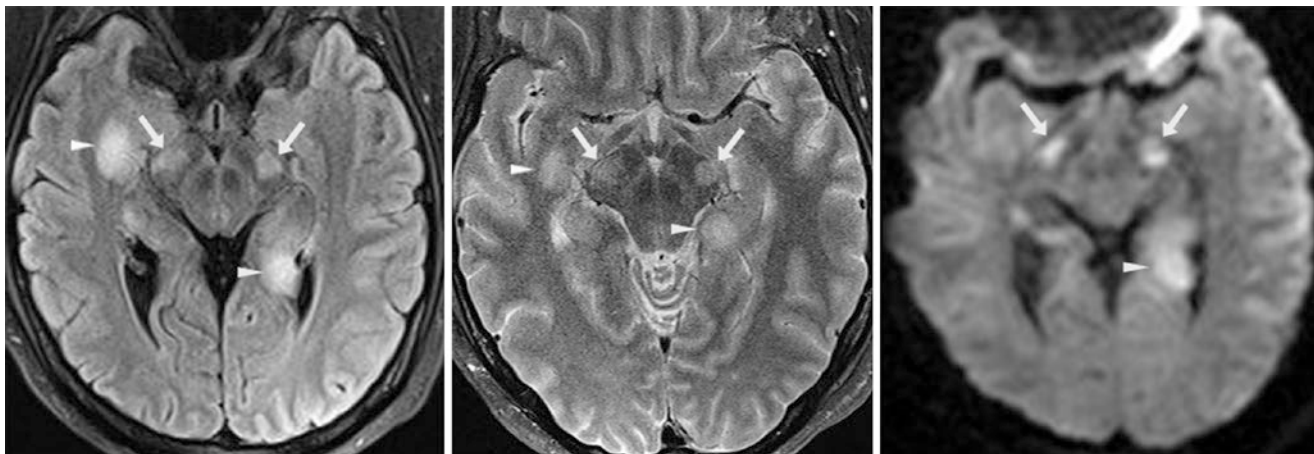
Comparison case of multiple sclerosis (MS). A 36-year-old had a 3 T MRI that showed bilateral CST lesions (*arrows*) on FLAIR (*left*), T2WI (*middle*), and DWI (*right*). Other periventricular lesions
